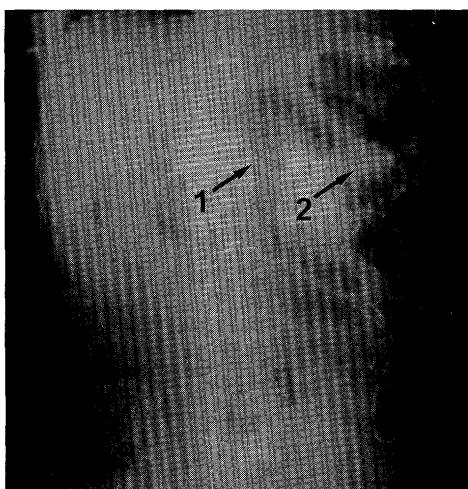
(A) Radiograph of the abdomen before perforation demonstrating each end of the catheter migrating to the upper part of the abdominal cavity, perhaps due to peritoneal adhesion from the repeated open abdominal surgery
